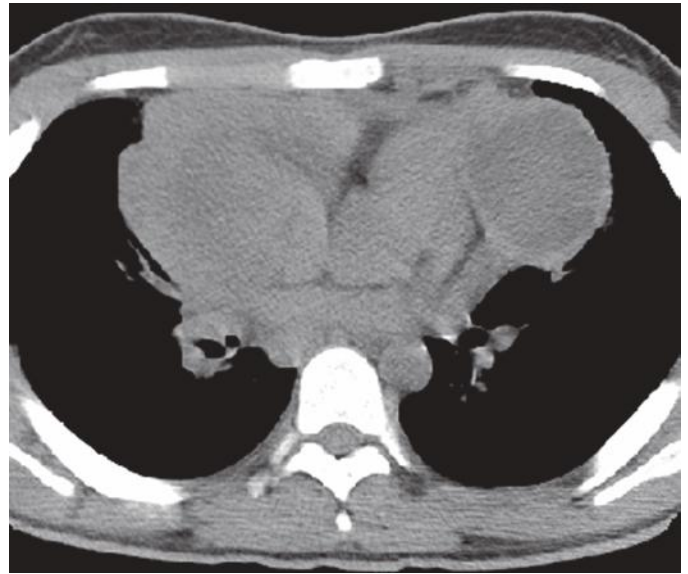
Computed tomography scan of child with mediastinal large B-cell lymphoma.
